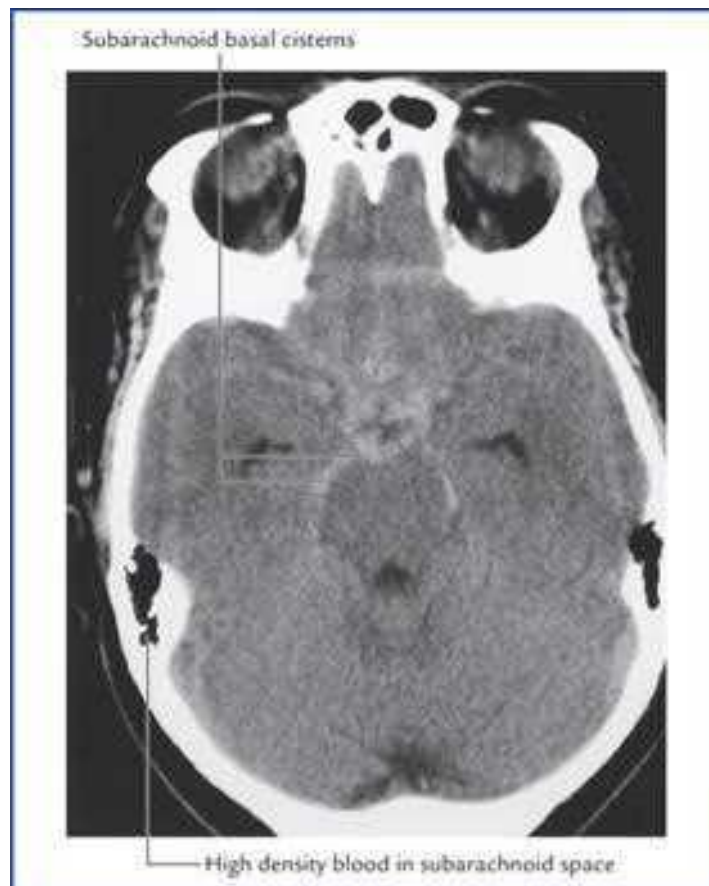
CT scan of brain showing subarachnoid haemorrhage (arrows). Source: Drake, Richard L, Vogl, Mitchell, Adam WM. *Grays Anatomy for Students*. Philadelphia: Elsevier, Inc., 2005
